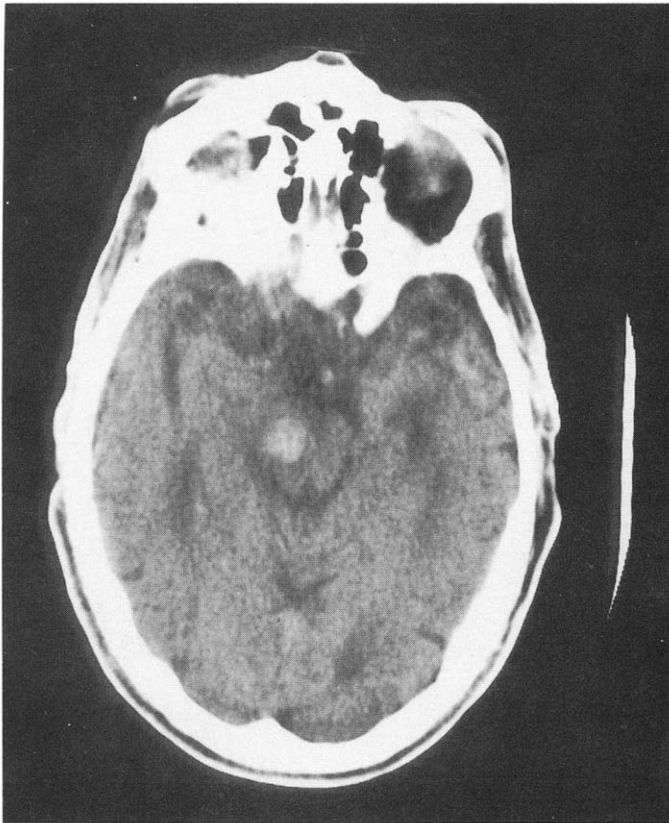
Case 2. Unenhanced CT scan, showing 1.25-cm hyperdense zone representing hemorrhage in right cerebral peduncle.
